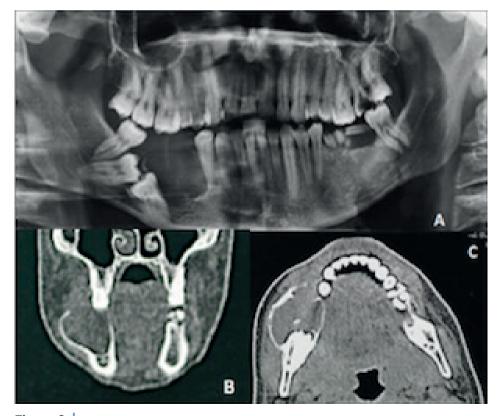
A: A panoramic radiograph shows a well-delimited radiolucent lesion with partially radiopaque borders. B, C: HCT coronal and axial view of tissues shows a well-delimited, unilocular, hypodense lesion with isodense content, with cortical expansion and rupture, affecting the posterior right mandible.
